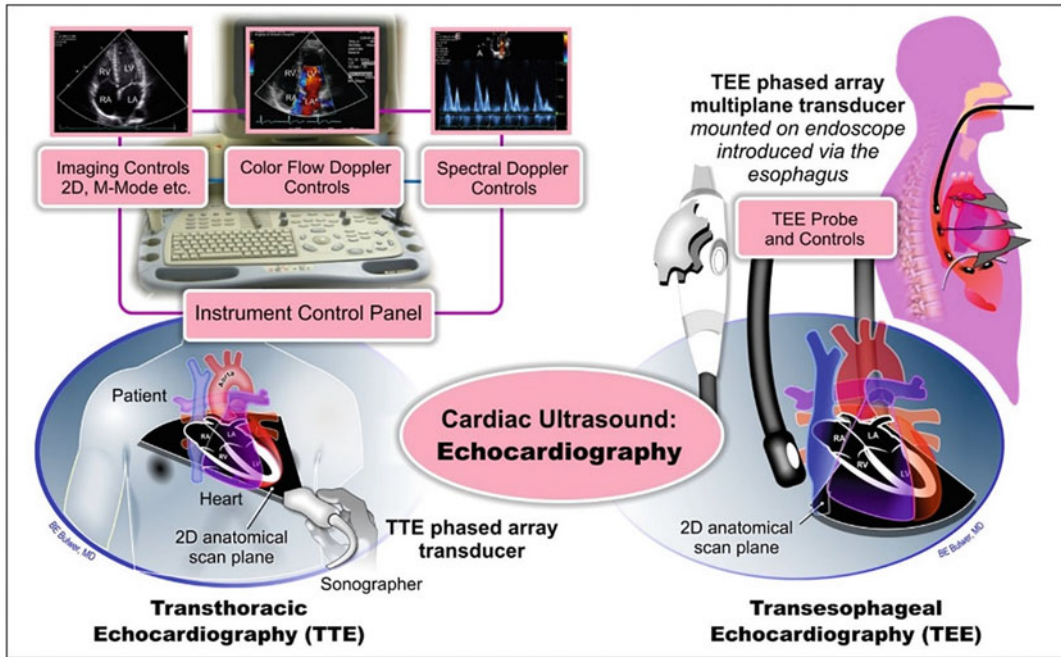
Two major types of echocardiography based on the position of the transducer probe. Transthoracic echocardiography acquires images of the heart mainly through the thorax (left). Transesophageal echocardiography acquires images using a transducer mounted on an endoscope inserted into the esophagus (right). High
